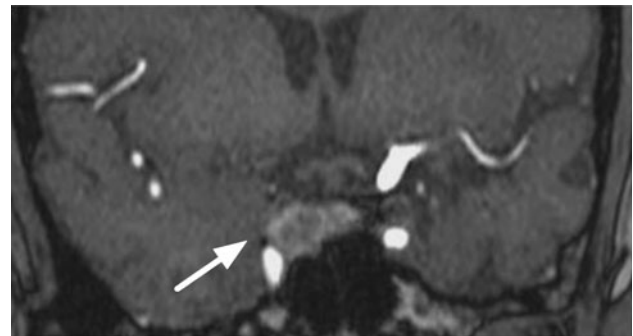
Coronal T2-weighted magnetic resonance imaging scan showing a 2.5 × 1.5-cm suprasellar mass (*arrow*) extending into the right cavernous sinus in a 60-year-old man who underwent shoulder joint arthroplasty
